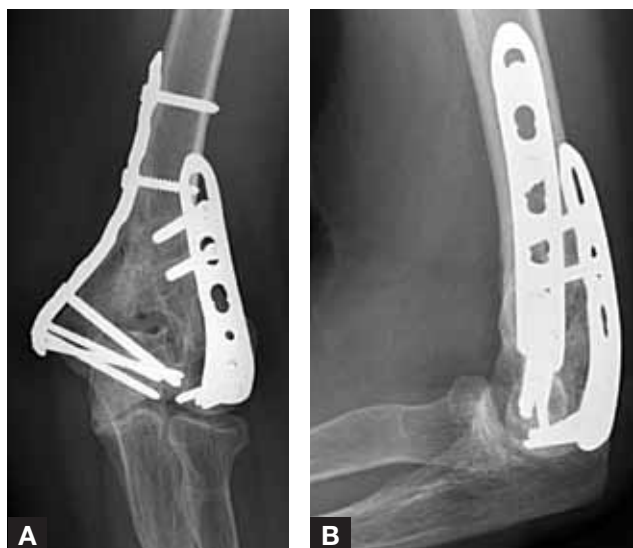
Anteroposterior (A) and lateral (B) radiographs of comminuted distal humerus fracture.
